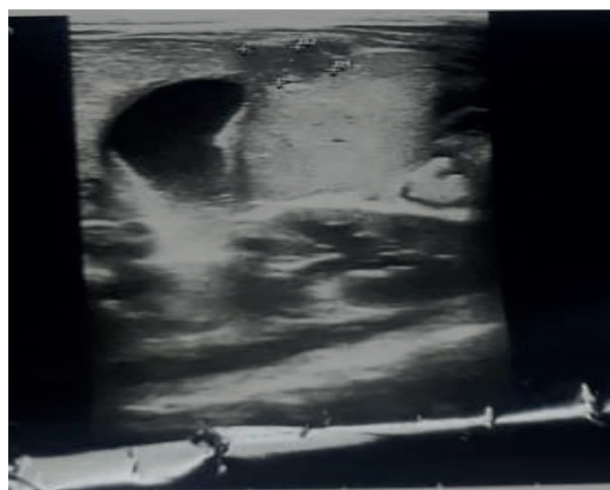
Ultrasound of the abdomen showing heterogeneous ill-defined areas in the right lobe of the liver, suggesting multiple liver abscesses, with the largest one measuring 33.6 × 13.2 × 26 mm, with a volume of 6.1 ml, and the other one measuring 20.9 × 14.7 × 17.5 mm, with a volume of 2.8 ml. The smallest one measured 15.2 × 9.4 × 11.2 mm, with a volume of 0.8 ml.
